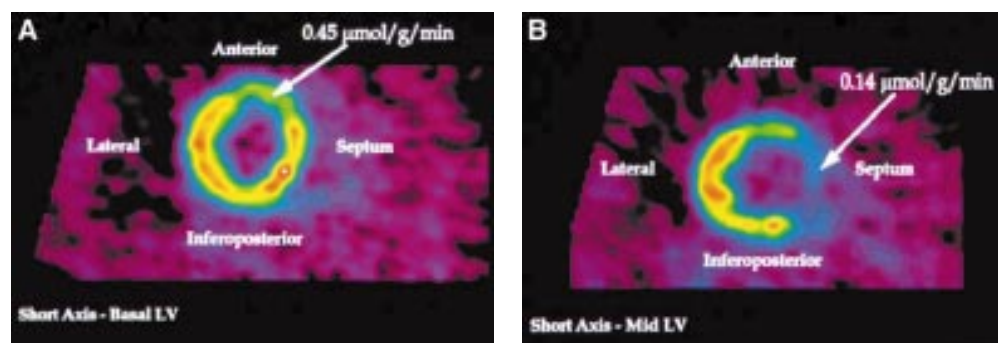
Myocardial viability in two patients with coronary artery disease and severe chronic left ventricular dysfunction assessed by PET with ^{18}F labelled FDG during hyperinsulinaemic euglycaemic clamp. Both patients had previous myocardial infarctions. The scan in panel A shows that FDG uptake in the previously infarcted anteroseptal segment is $0.45 \mu\text{mol/g/min}$, suggesting the presence of viable myocardium. In the scan in panel B the uptake of FDG in the anterior wall and the interventricular septum is significantly reduced ($0.14 \mu\text{mol/g/min}$), suggesting absence of viability in this large area. A cut off point of $0.25 \mu\text{mol/g/min}$ is routinely used in our laboratory to differentiate between viable and non-viable myocardium.¹³
